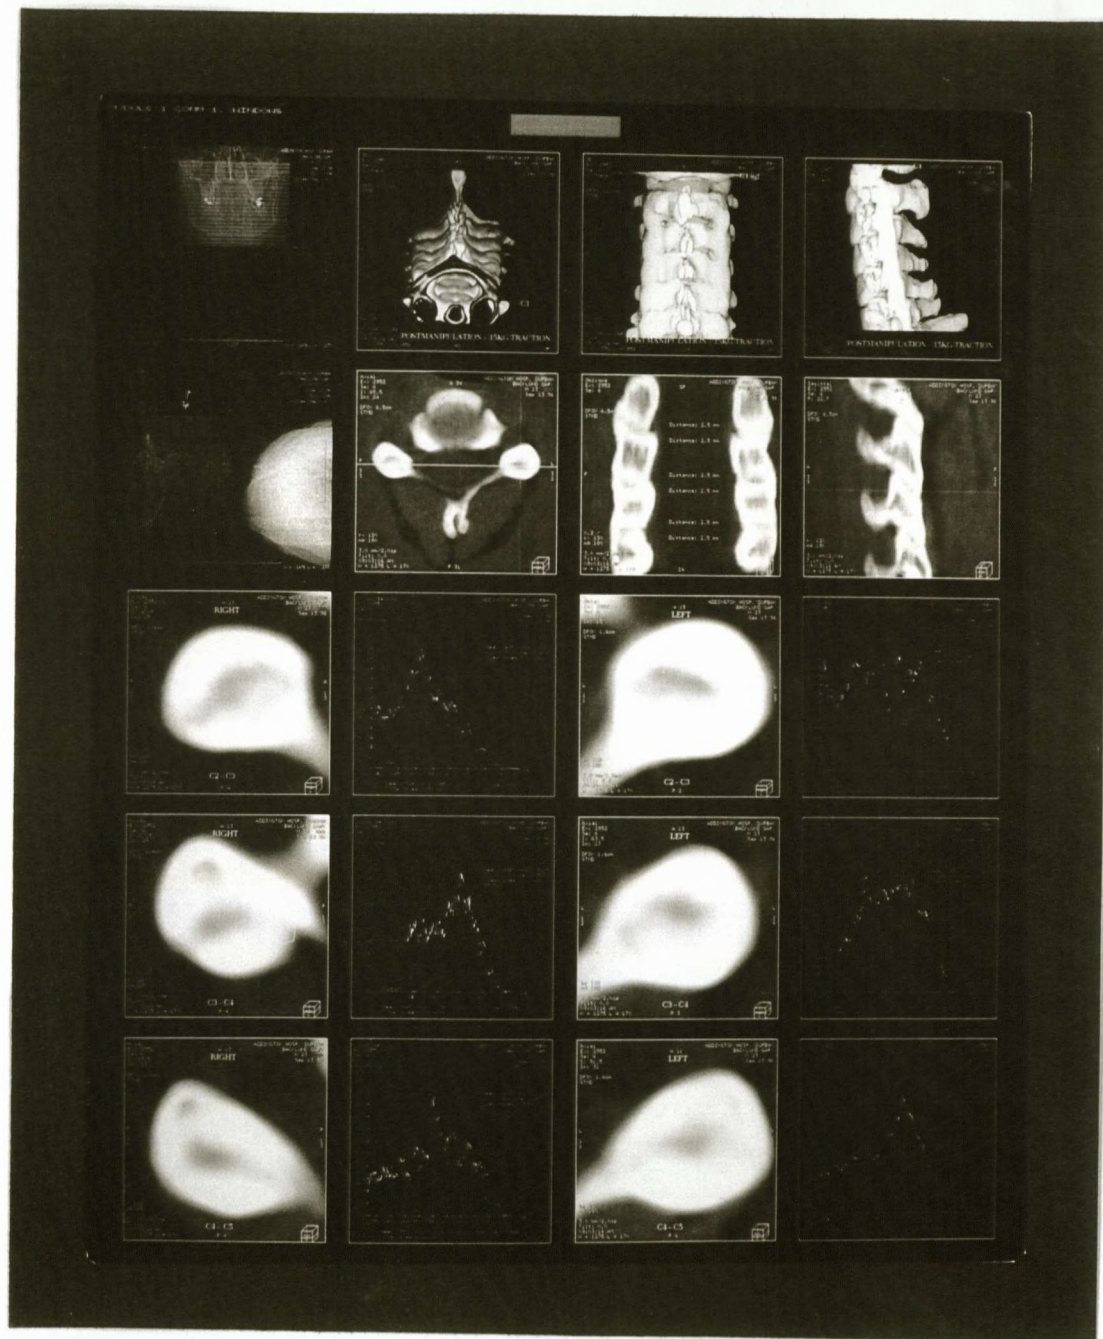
Experiment 6 : Post-manipulation + 15kg traction CT scan
